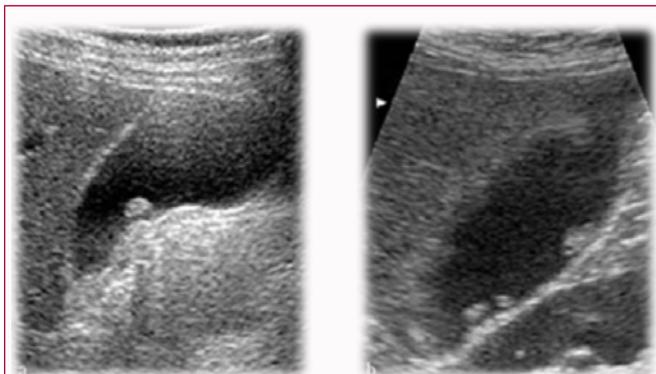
Cholesterosis; typical ultrasound appearance: axial and longitudinal sections showing multiple small rounded formations, hyperechoic without posterior shadow cone, attached to the gallbladder wall [6].
